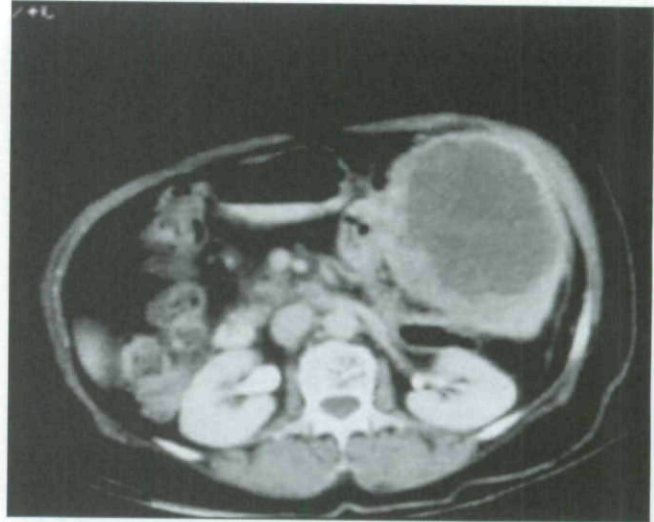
Primary splenic lymphoma. The patient presented with symptoms related to splenomegaly and hypersplenism. This abdominal computed tomography scan with intravenous contrast demonstrated a low-attenuating lesion in the spleen. After splenectomy and a search for synchronous sites of disease, the diagnosis of primary splenic lymphoma was made.
